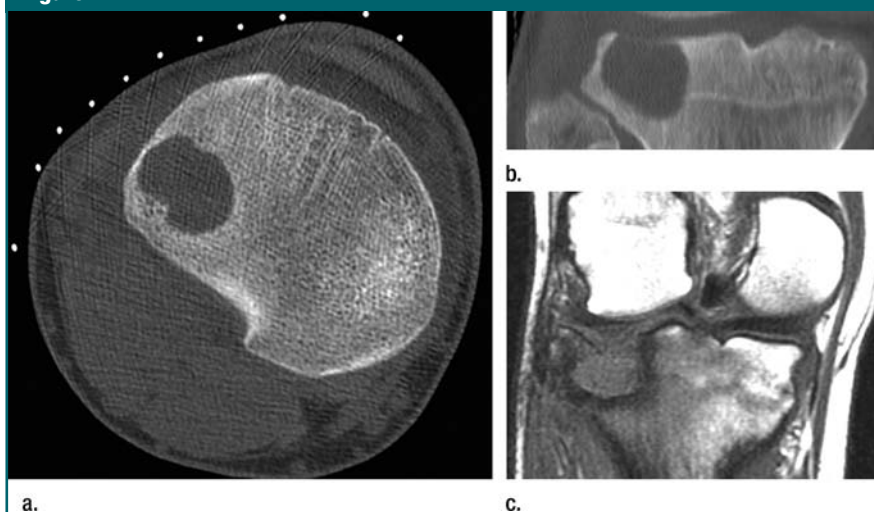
Images in 17-year-old adolescent boy with subsequent collapse of the articular surface after RF ablation of a large lesion in lateral tibial plateau. (a) Axial CT scan and (b) reconstructed coronal CT scan obtained immediately before the procedure demonstrate a large lytic lesion in the posterolateral aspect of the tibial plateau with marked thinning of the articular surface. (c) Coronal T1-weighted MR image obtained 9 months after RF ablation demonstrates collapse of the subchondral surface with marked surrounding low-signal-intensity edema.
